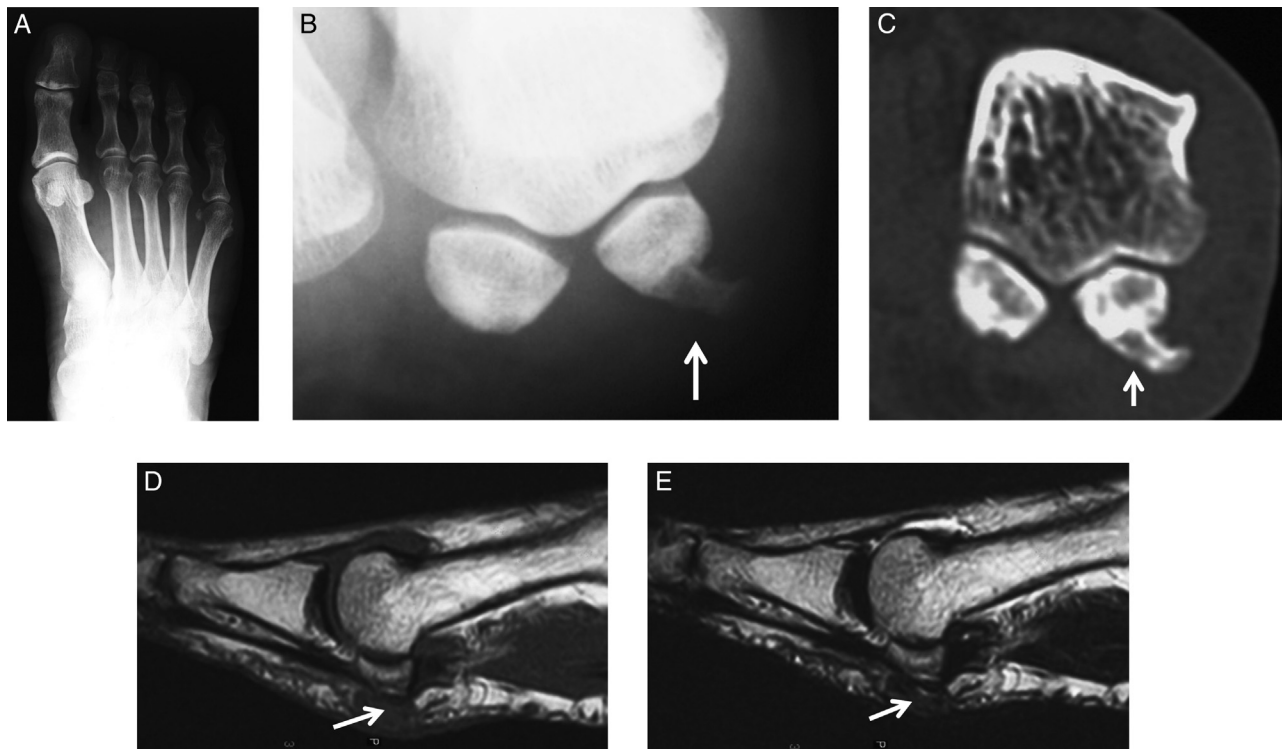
(A) Dorsoplantar and (B) axial plain radiographs of the right great toe showing a bony protrusion on the plantar side of the tibial sesamoid (arrow). (C) Coronal computed tomography scan showing a distinct bony protrusion continuous with the sesamoid on the plantar side of the tibial sesamoid (arrow). Magnetic resonance imaging scans showing a thin cartilage cap with (D) low intensity on T₁-weighted image and (E) high intensity on T₂-weighted image on the surface of the bony protrusion (arrows).
